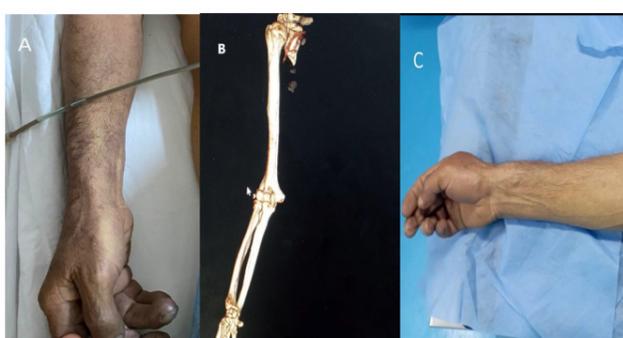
(A) Picture showing digital cyanosis before revascularization surgery; (B) Angio computed tomography with rendering 3D reconstruction showing total occlusion of the brachial artery with absence of radial and ulnar vessels; (C) Preoperative picture showing patient's ischemic forearm that required immediate revascularization.
